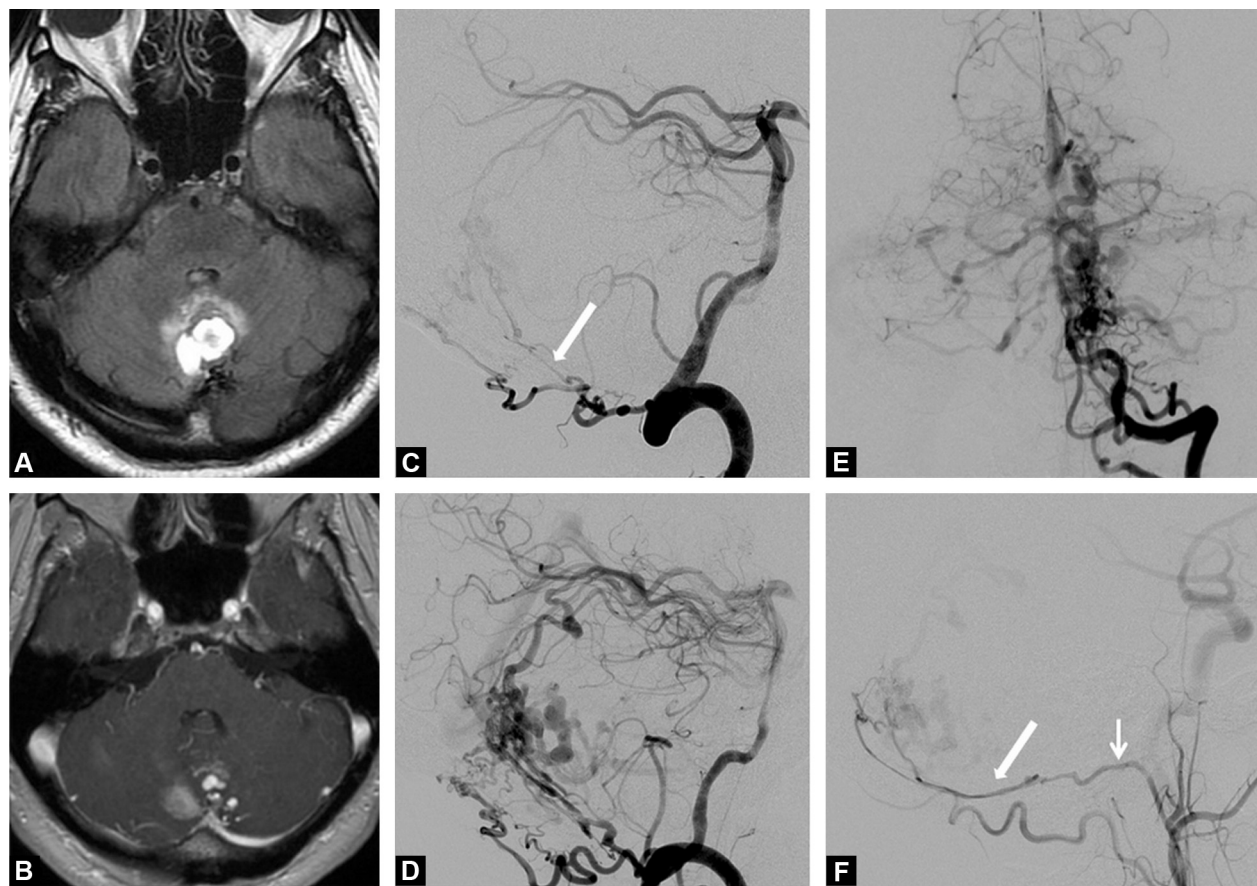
A. Pre-embolization T1-weighted MR image in the transverse plane shows median cerebellar hematoma. B. Pre-embolization T1-weighted MR sequence obtained after IV of a gadolinium chelate in the transverse plane shows vascular dilatations in the posterior fossa near the hematoma. C–E. Cerebral angiogram, left vertebral artery injection, shows the aggressive sub-tentorial dural arteriovenous fistula (DAVF) mainly supplied by the posterior meningeal artery (arrow) via the left vertebral artery injection. Note the hyper-tortuosity of the posterior meningeal artery. F. Cerebral angiogram using a right external carotid artery injection, shows the hypertrophic neurovascular trunk (thin arrow) and the arterial feeder access to the DAVF (thick arrow).
